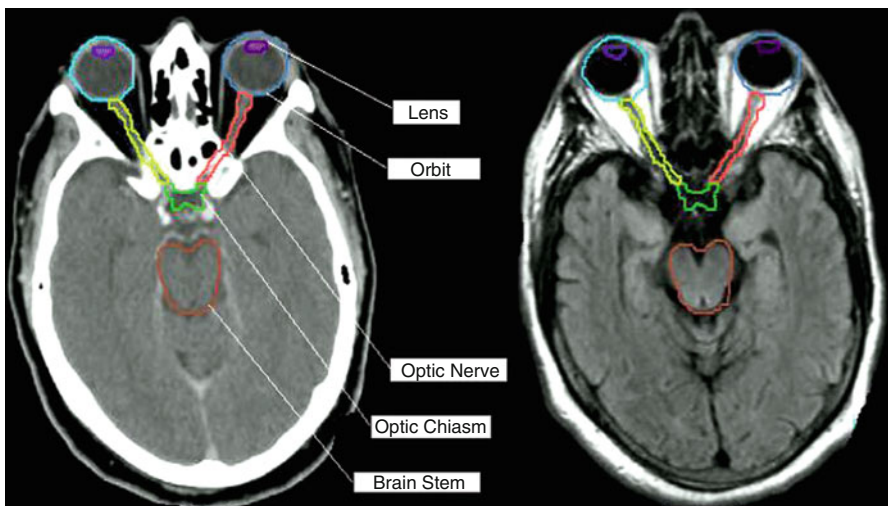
Organs at risk outlined on planning CT scan and co-registered MRI
